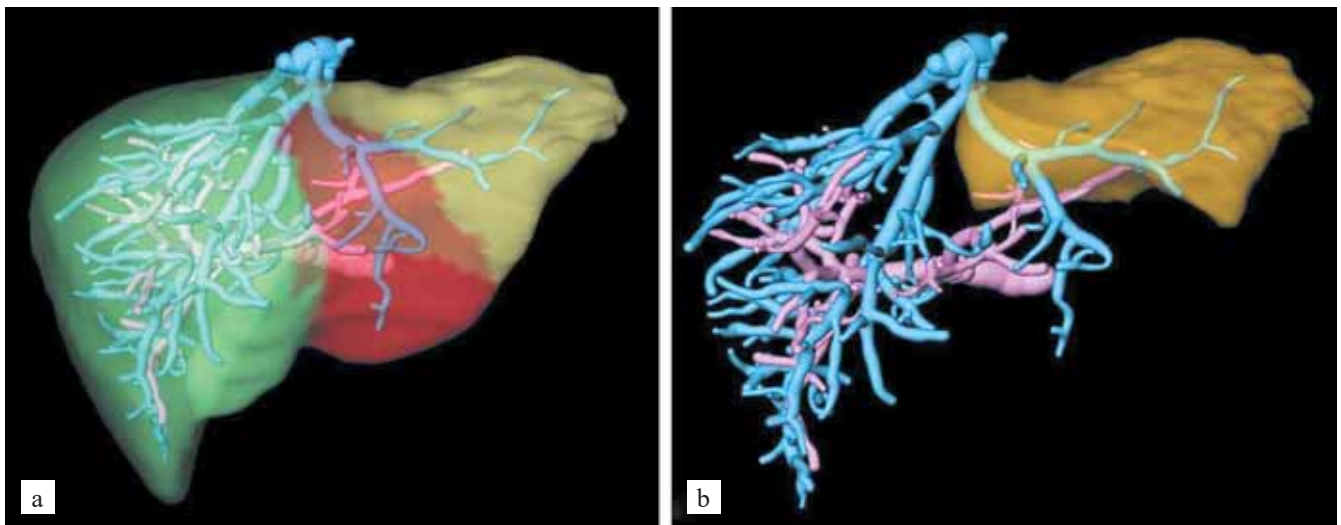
3D reconstruction of contrast-enhanced CT images of the hepatic veins (blue) and portal vein branches (pink) 2D CT images. a, whole liver; b, second segment
